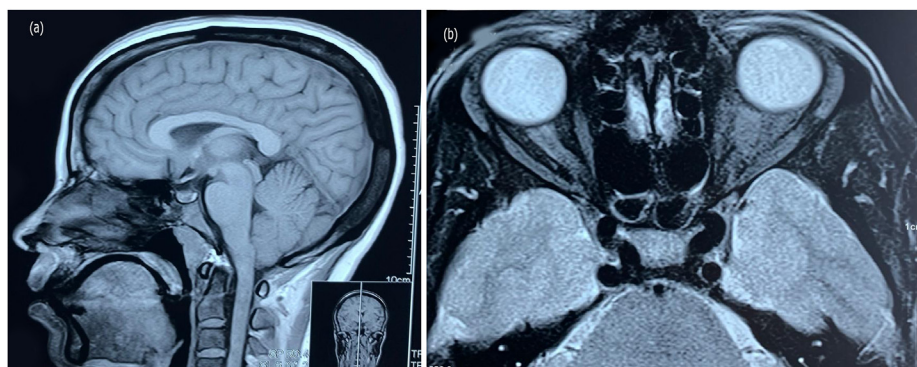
Brain MRI sagittal T1 (a) film showing enlarged pituitary gland measuring 1.3×2.7 mm and axial T1 (b) film showing enlarged pituitary gland with left optic neuritis.
